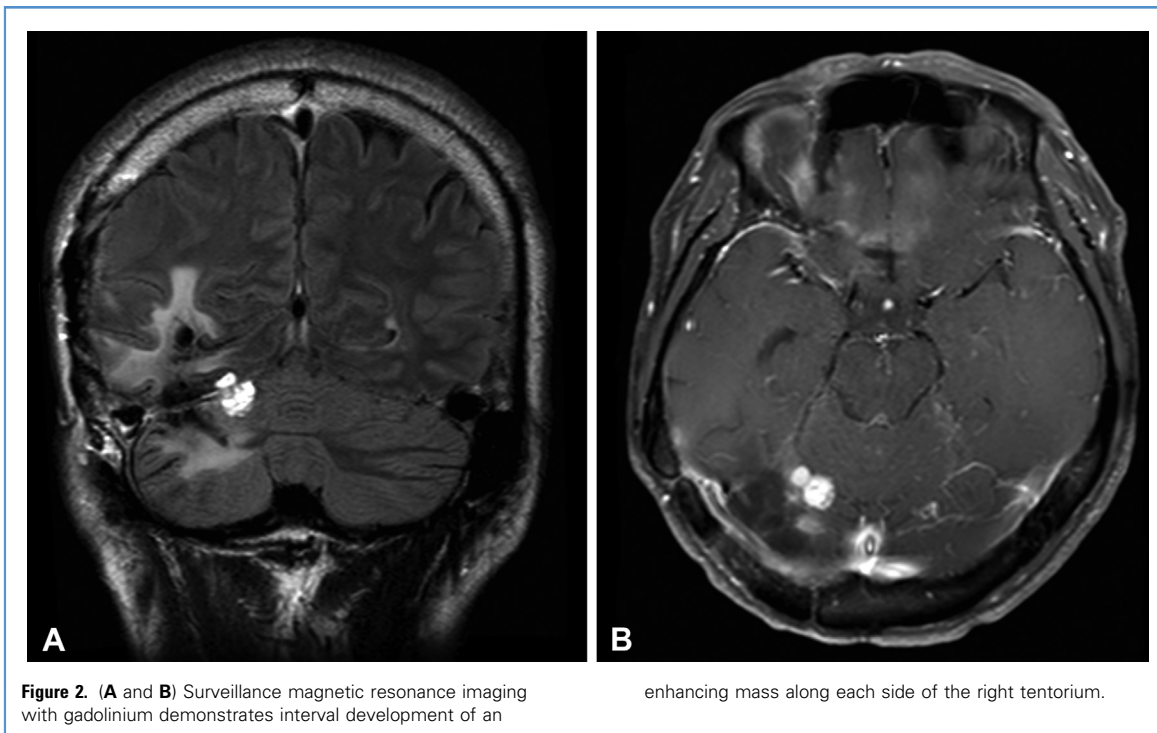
(A and B) Surveillance magnetic resonance imaging with gadolinium demonstrates interval development of an
